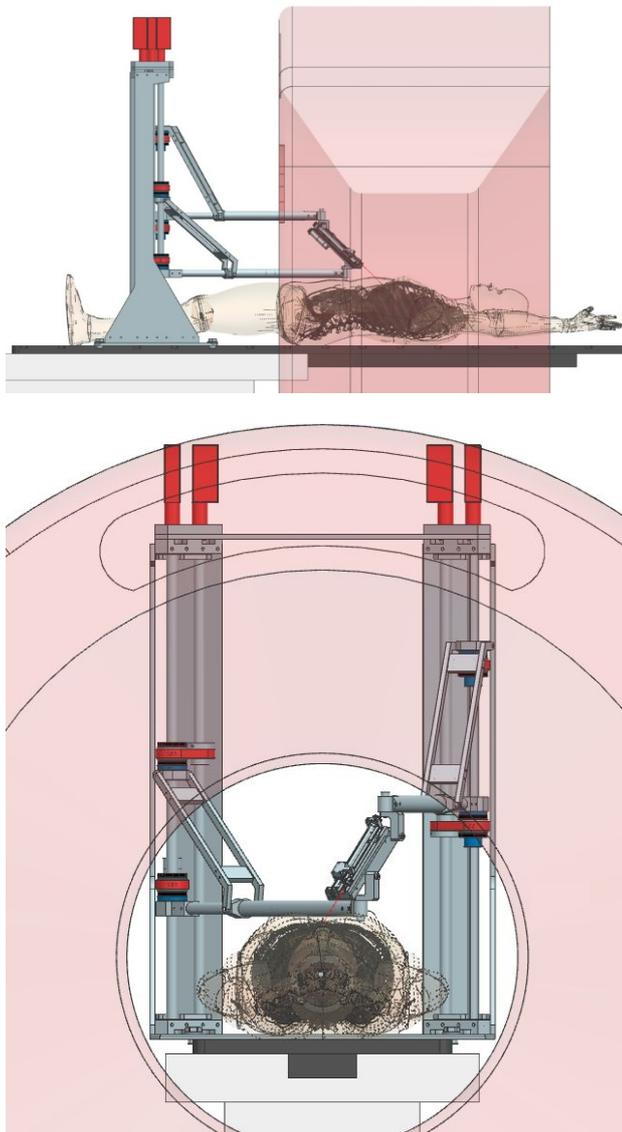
Dimensional check for CT scanner workspace with a virtual patient in a liver needle insertion.
